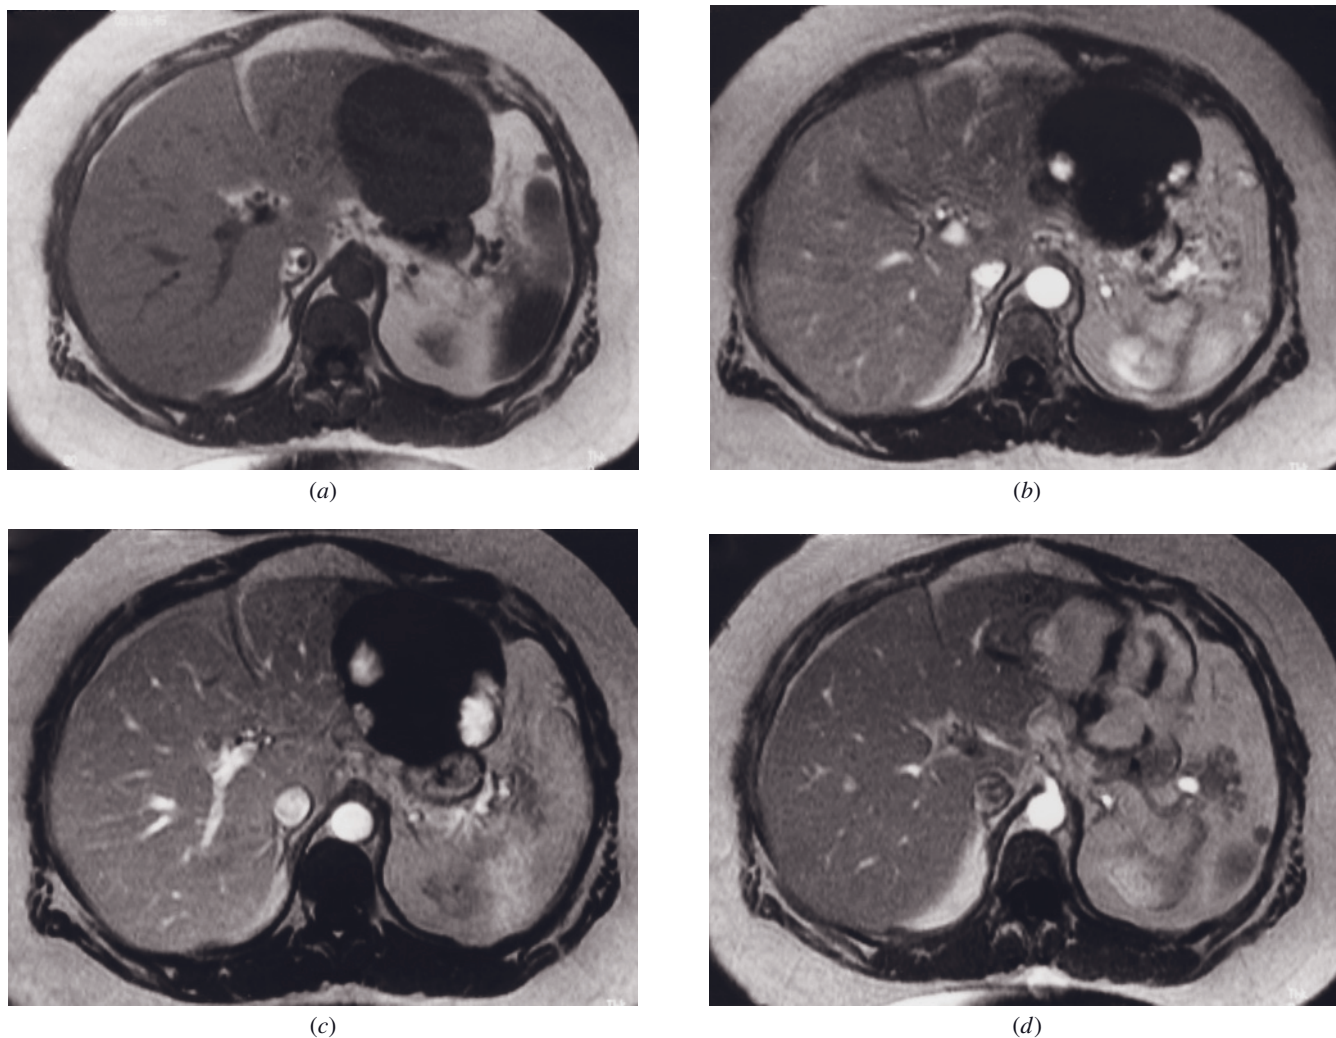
Giant hemangioma. SGE (a) and immediate (b), 90-s (c), and 10-min (d) postgadolinium SGE images. A hemangioma is present in the left lobe that is moderately low in signal intensity on T1-weighted image (a), demonstrates peripheral nodular enhancement in a discontinuous ring on the early image (b), and gradually enhances in a centripetal fashion (c) with persistent low signal intensity central scar on delayed image (d).
